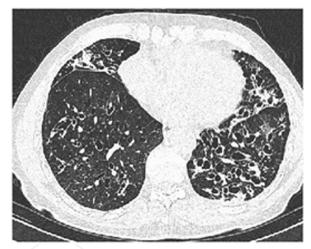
HRCT findings in ZZ individuals with emphysema (left) and bronchiectasis (right).
